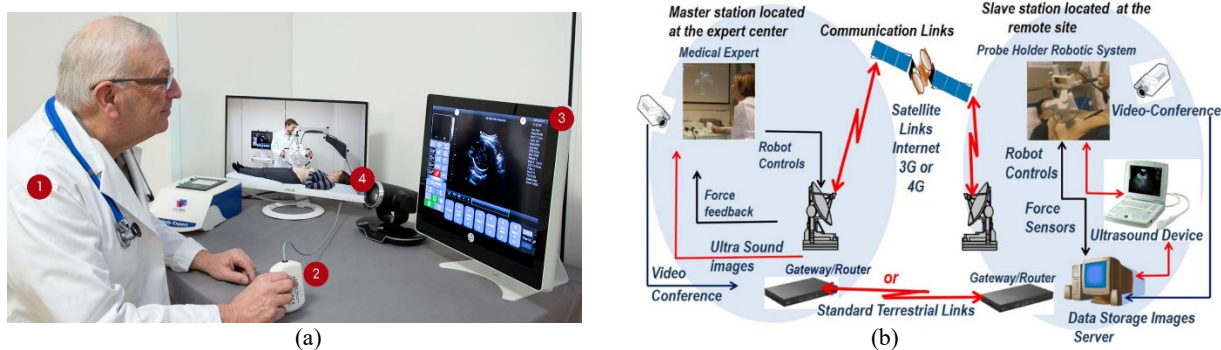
(a) Sonographer performing US scanning remotely [16]; (b) Robotized tele-ultrasound using the MELODY system [14]
